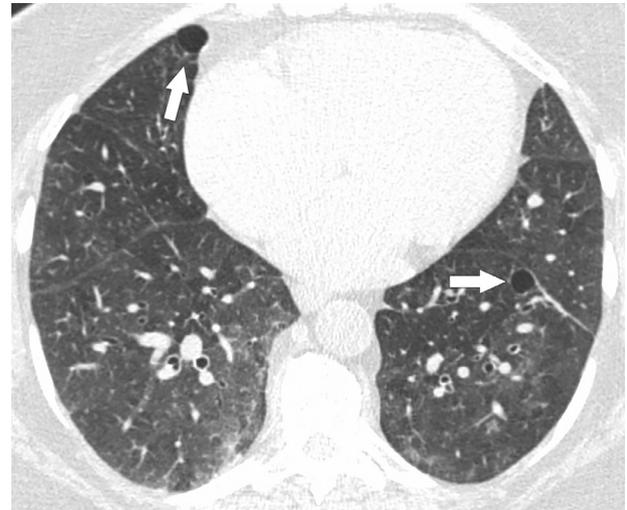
A 65-year-old female with SS and LIP. HRCT image shows patchy ground-glass opacity and two thin-walled perivascular cysts (arrows). The number of cysts in LIP is quite variable. LIP, lymphoid interstitial pneumonia.
